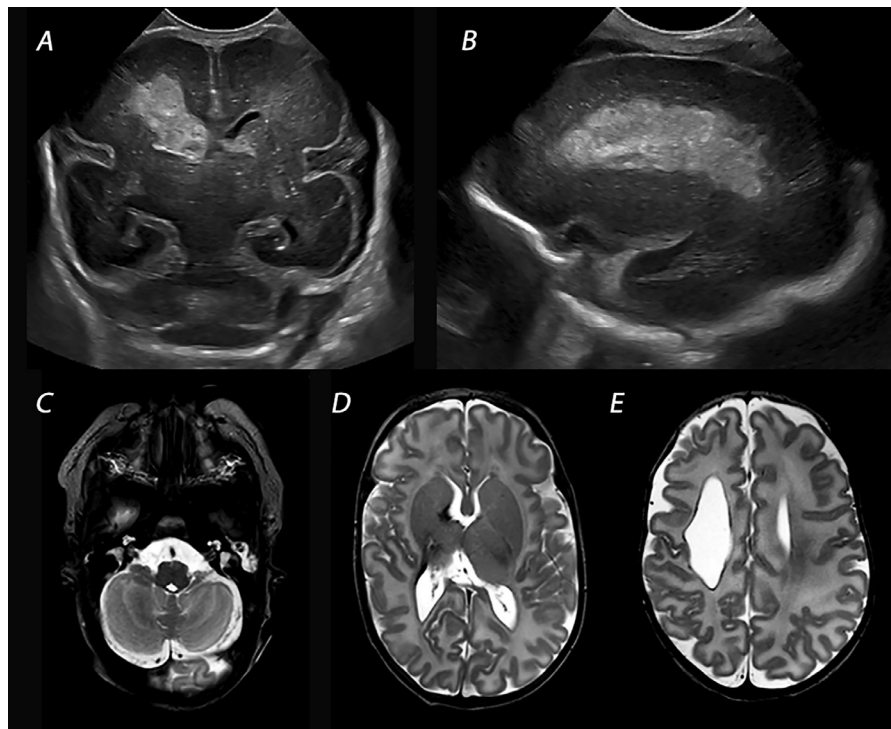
Preterm infant born at 26 weeks/ birthweight 809 g. cUS on day 2 shows globular shaped PVHI in a coronal (A) and parasagittal view (B) involving the frontal and parietal lobe. The TEA-MRI, axial T2 sequence, shows crossed cerebellar diaschisis (C), asymmetry of the PLIC (D) and the porencephalic cyst (E).
